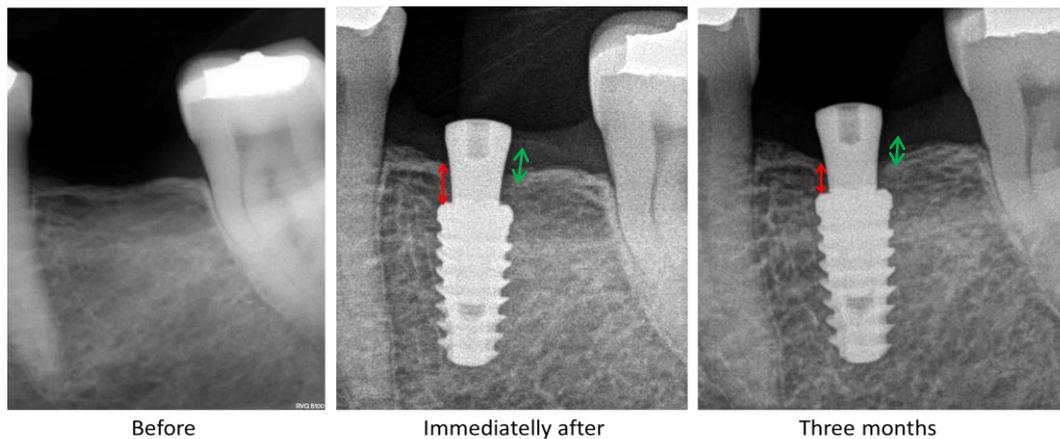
Radiograph sequence used to evaluate and measure the bone level. The measurements were performed from the implant platform to the crestal bone (red arrows = m-MBL and green arrows = d-MBL).
